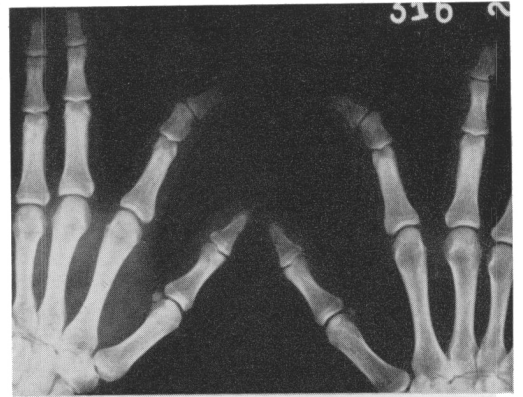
Roentgenograms of feet of subject III,6 (a) and of hands of subjects III,9 (b) and II,5 (c) showing a different degree of severity in the expression of the dysplasia of middle phalanges of second digits.
